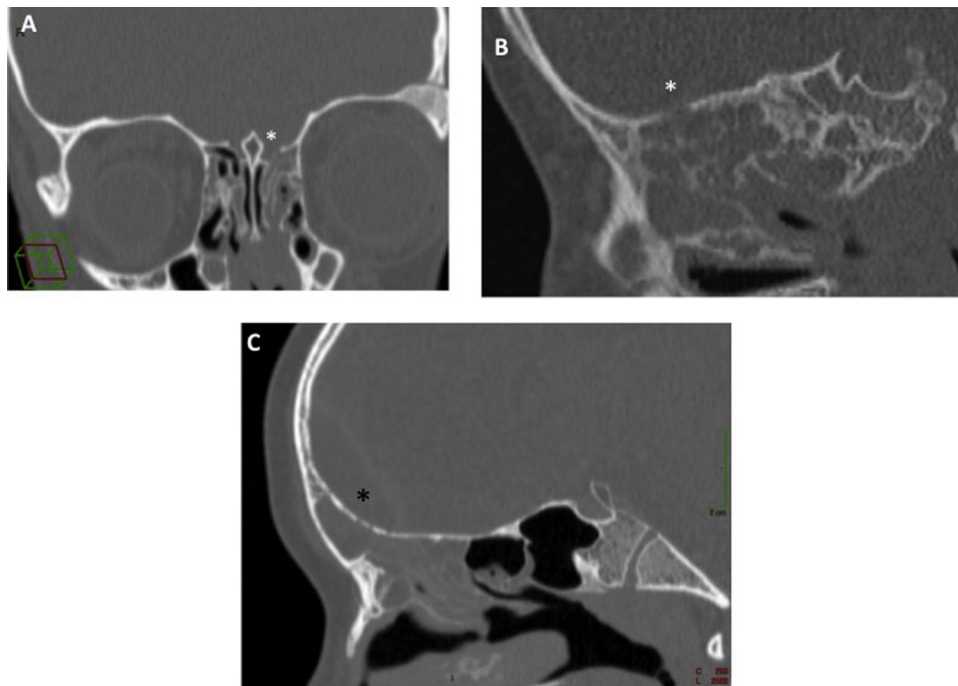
CT scans showing an erosion of the ethmoidal roof ((A) SE, (B) EE) or of the posterior wall of the frontal bone (*) ((C) EE).
